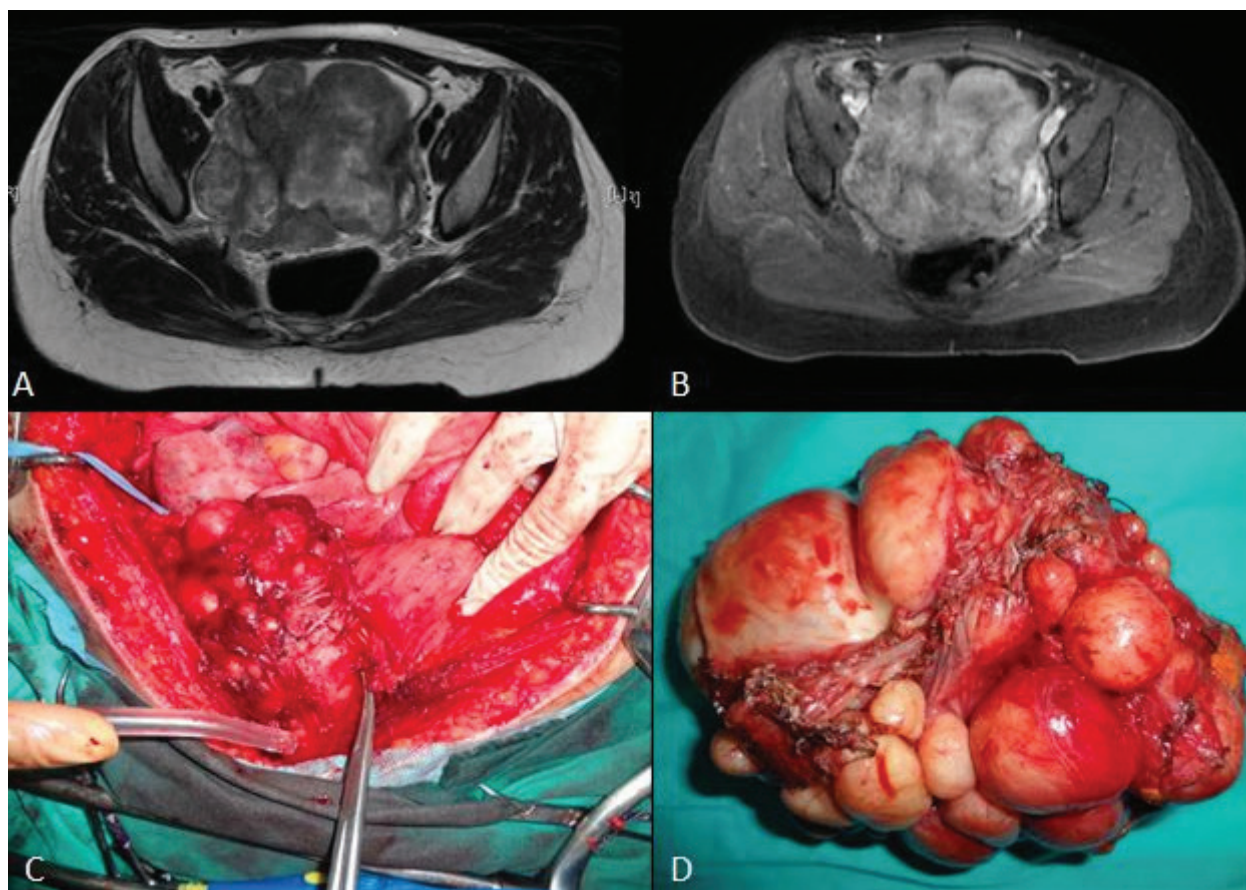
(A). Fat-suppressed T1-weighted sequence after intravenous gadolinium administration demonstrating a giant mass with heterogeneous contrast agent fixation that occupies the entire pelvis. (B). T2-weighted sequence showing a solid lesion with partially high signal areas and no clear border separation visible in the adjacent bladder. (C). The bladder leiomyoma reached the bladder mucosa and compressed the uterine cervix from the antero-lateral part. (D). The bladder leiomyoma was approximately 10x15 cm in size.
